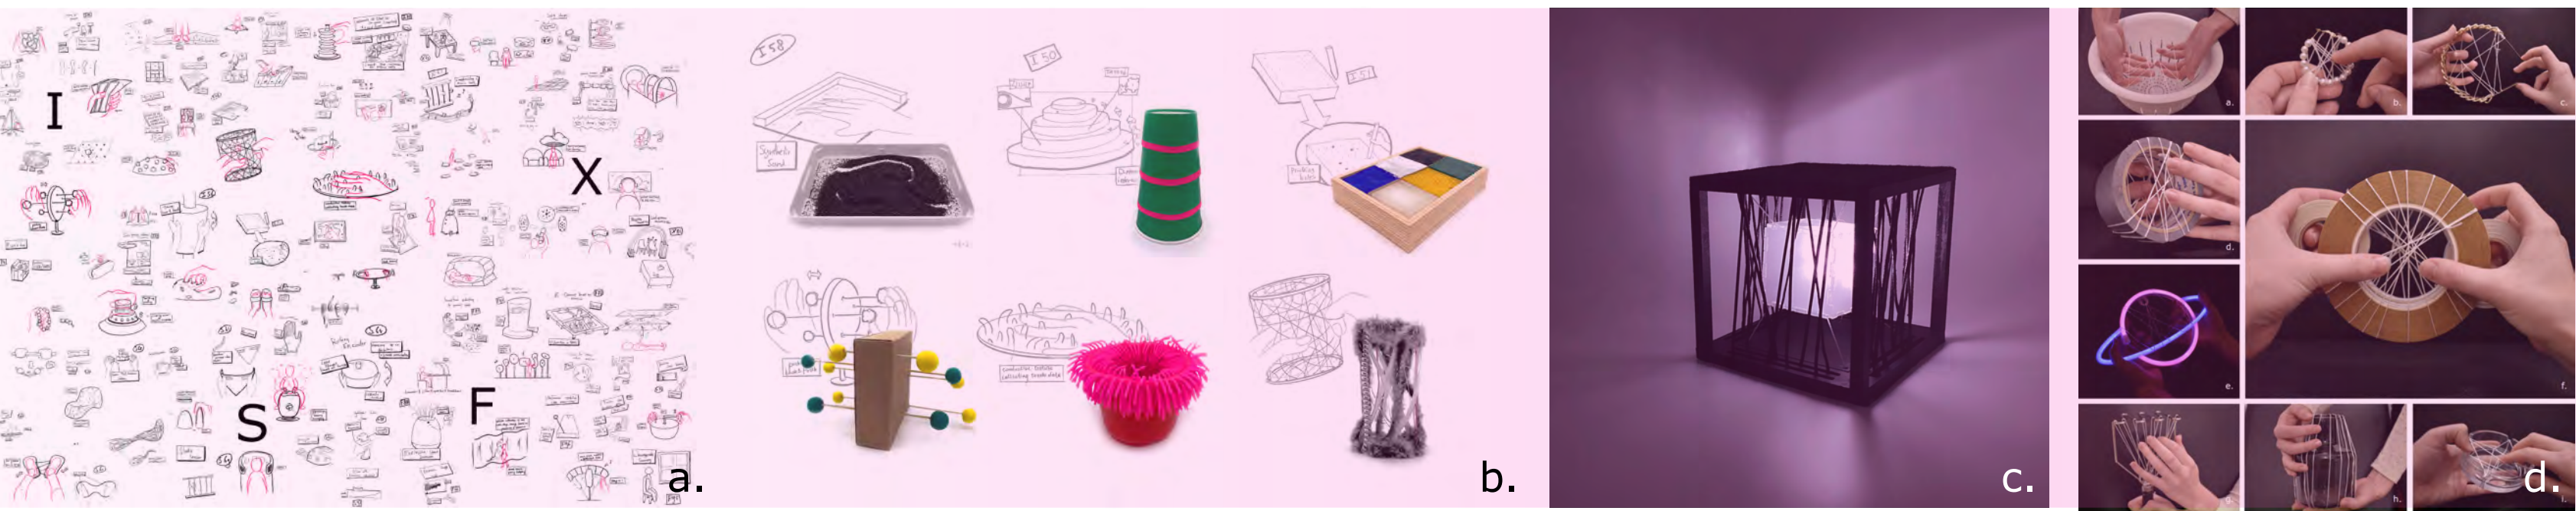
Design process of a) 100 sketches of measuring MRI experience through interaction, b) exploratory prototypes based on a selection of sketches, c) high fidelity prototype incorporating sensors and d) ideation of round shape and string integration
